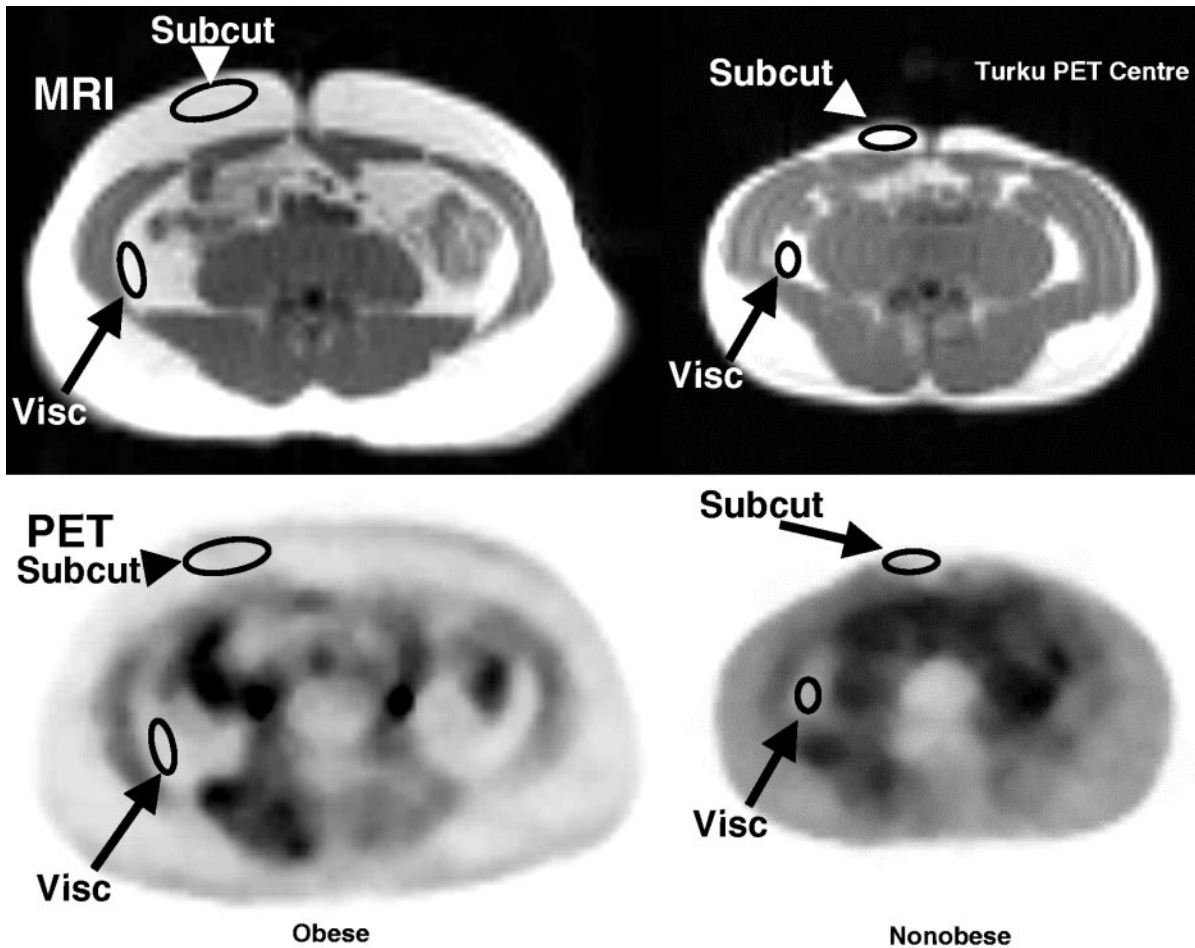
An example of MRI and [^{18}F]FDG-PET images in the abdominal region of a nonobese (*right*) and an obese subject (*left*). ROI are outlined with *black* in sc adipose tissue (subcut) and in visceral adipose tissue (visc). MRI and PET images are from the same level. In the lower panel are the PET images in which the highest activity is shown as *black* as an index of trapping.
